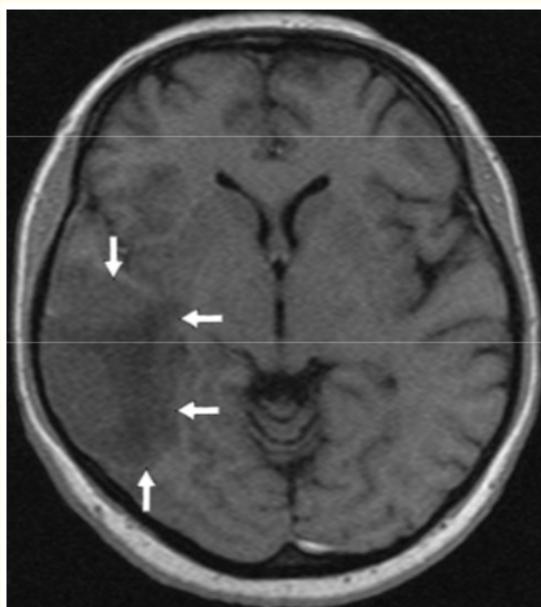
MRI with ischemic stroke in the left MCR basin (left hypodence zone- arrows).
